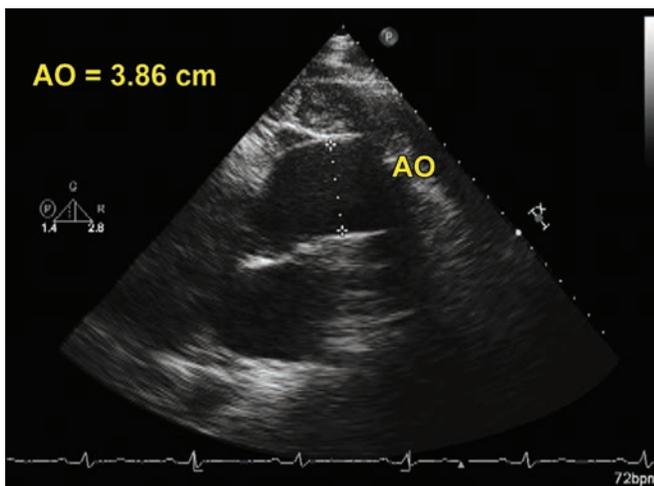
Right parasternal examination. The ascending aorta (AO) is enlarged and measures 3.86 cm.
